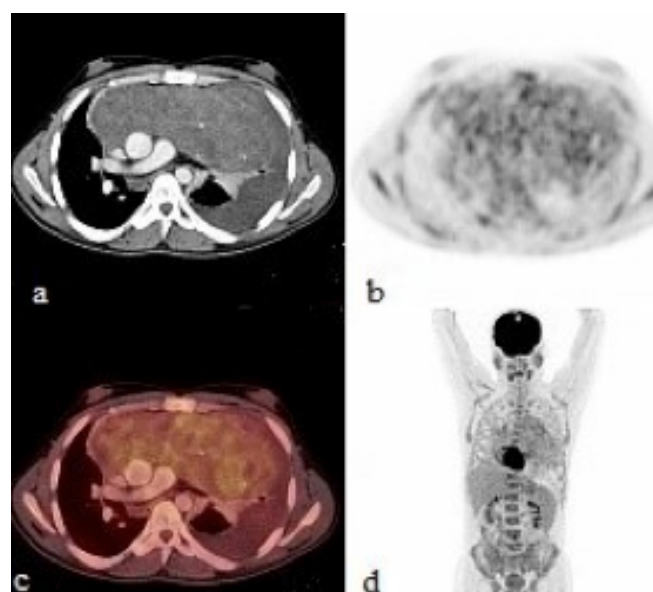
PET/CT demonstrating that the diameters of the anterior mediastinal mass increased but metabolic activity decreased.
